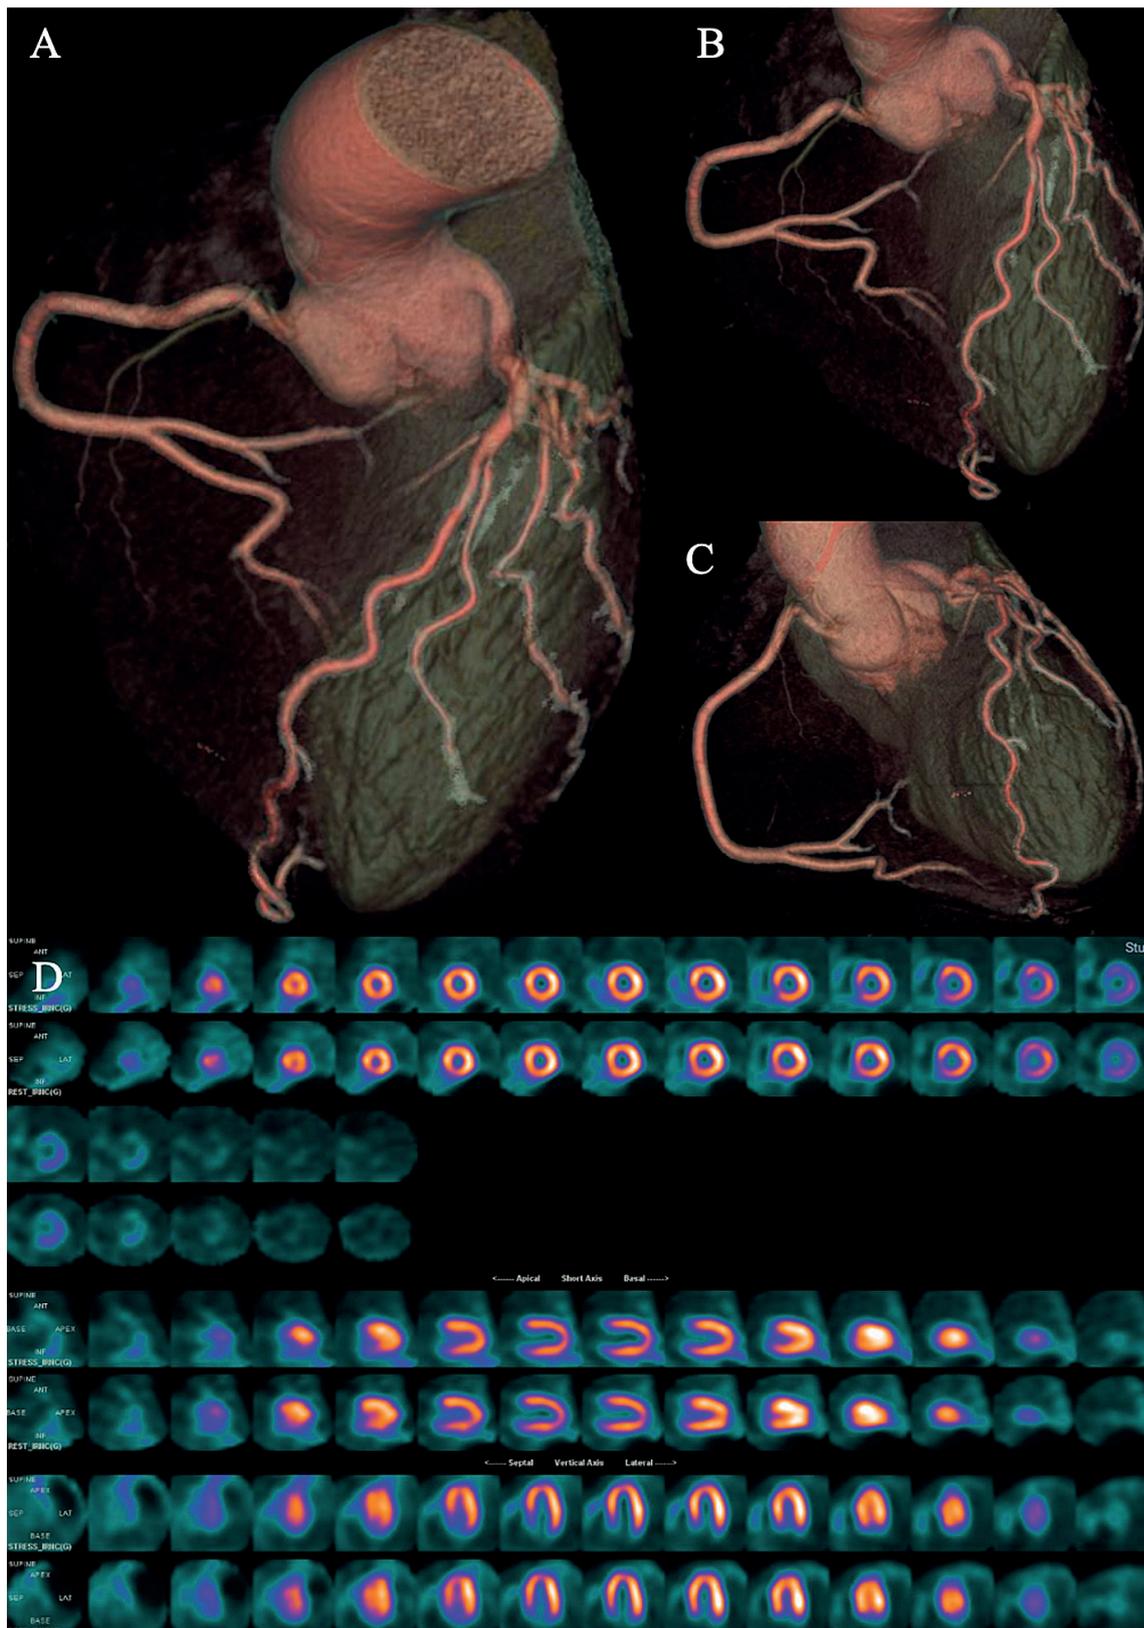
Coronary computed tomography angiography and myocardial perfusion scintigraphy during follow-up.
